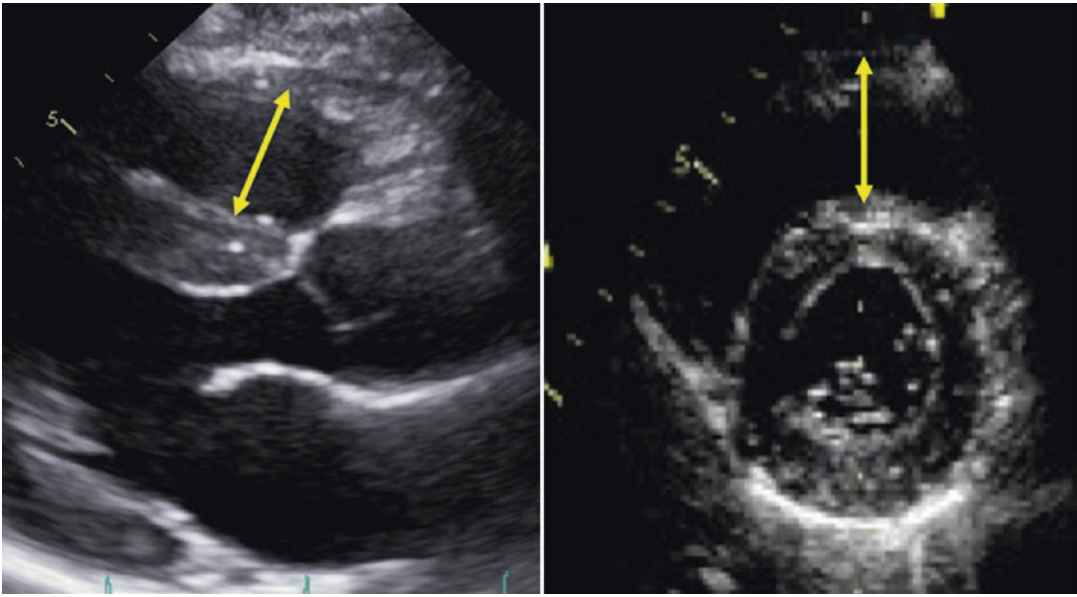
Proximal RVOT dimension as measured from the parasternal long (*left panel*) and short (*right panel*) axis
